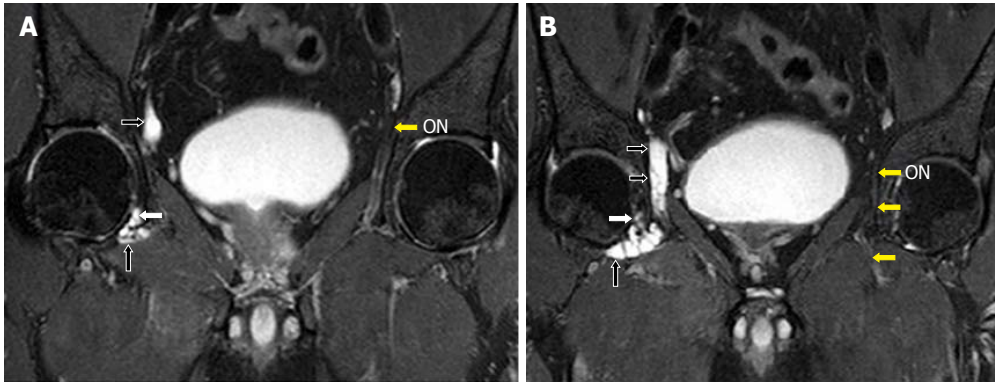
Images A, B show serial, T2-weighted fat suppressed coronal sections of the pelvis that demonstrates the longitudinally oriented intraneural cyst in the right obturator nerve (black arrows). The extension along the articular branch to the anteromedial aspect of right hip joint (white arrows) is also seen. Note the normal left obturator nerve (ON, yellow arrows). Reprinted with permission from Acta Neurologica Belgica.
